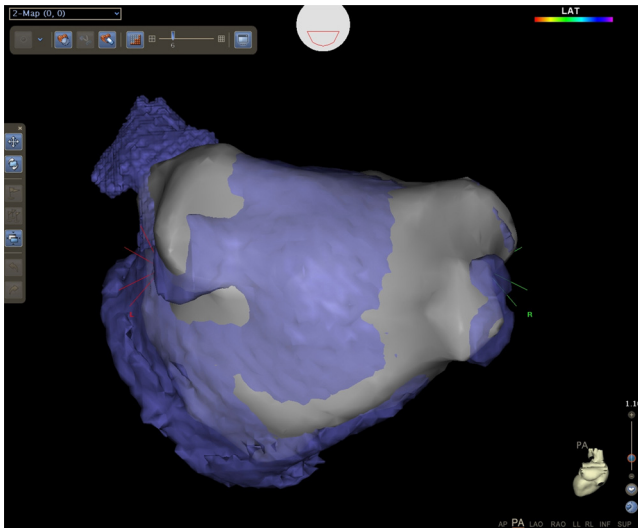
CARTO electroanatomical mapping system. FAM map (3D reconstruction of left atrium) + CT image integration.
